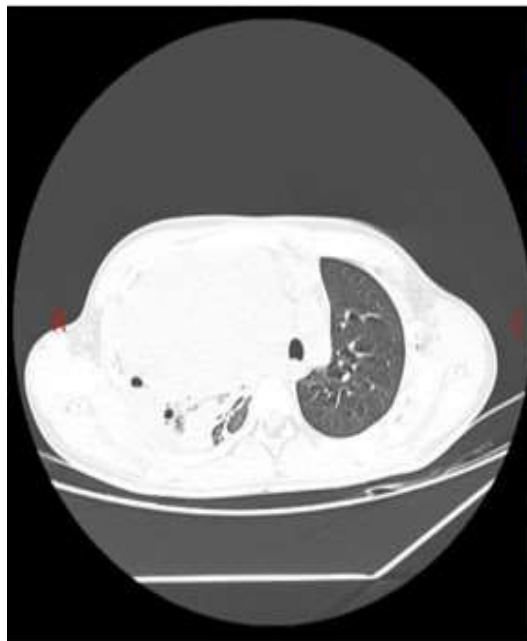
CT chest, a heterogeneously enhanced massive anterior mediastinal mass having internal fat attenuation foci with ipsilateral pleural effusion and lymphadenopathy involving prevascular and right supraclavicular regions.
